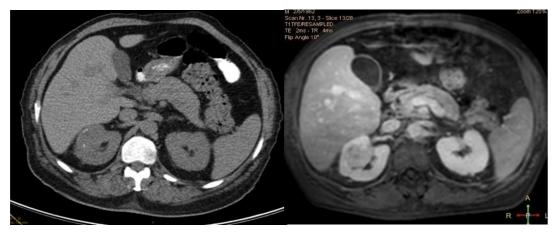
Right kidney tumour. A) Abdominal CT (without contrast) showing small foci of calcifications; B) T1 GAD-enhanced MRI showing renal sinus invasion.
